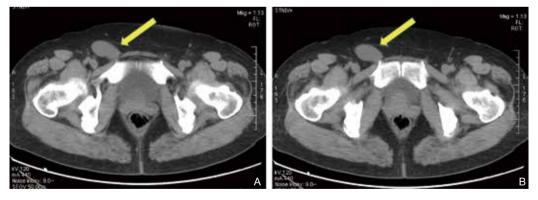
Axial CT demonstrates a well-circumscribed lesion, homogeneous mass in the proximal portion of the right inguinal canal (arrows).
